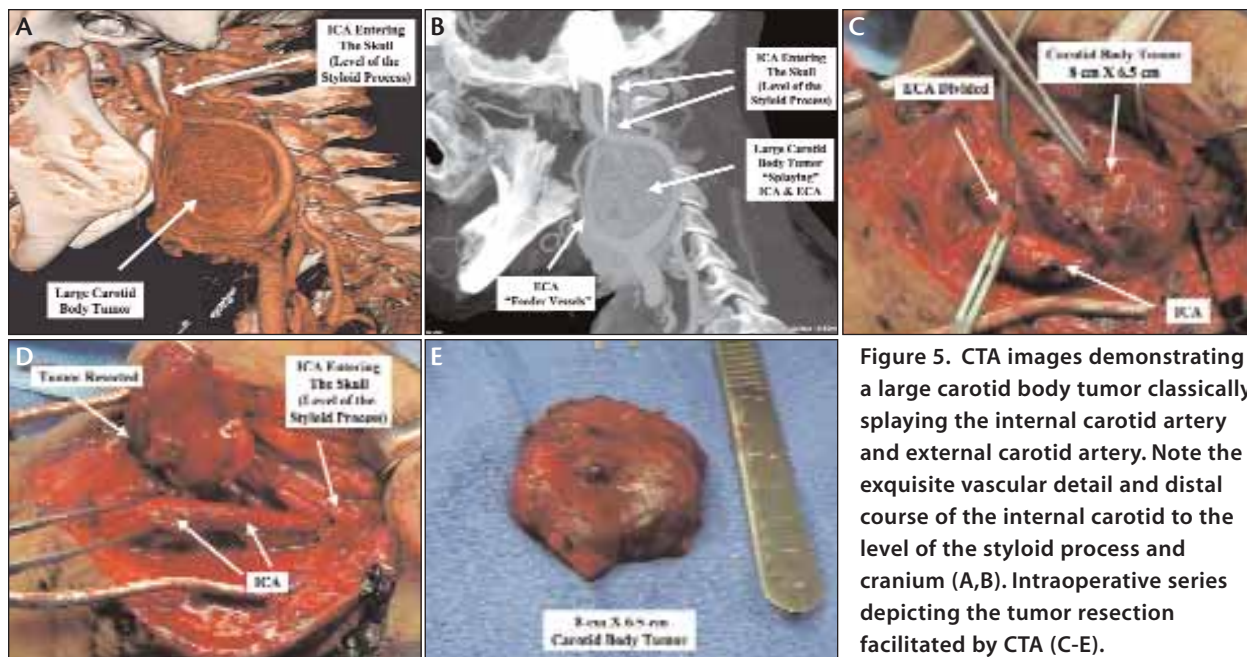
CTA images demonstrating a large carotid body tumor classically splaying the internal carotid artery and external carotid artery. Note the exquisite vascular detail and distal course of the internal carotid to the level of the styloid process and cranium (A,B). Intraoperative series depicting the tumor resection facilitated by CTA (C-E).
